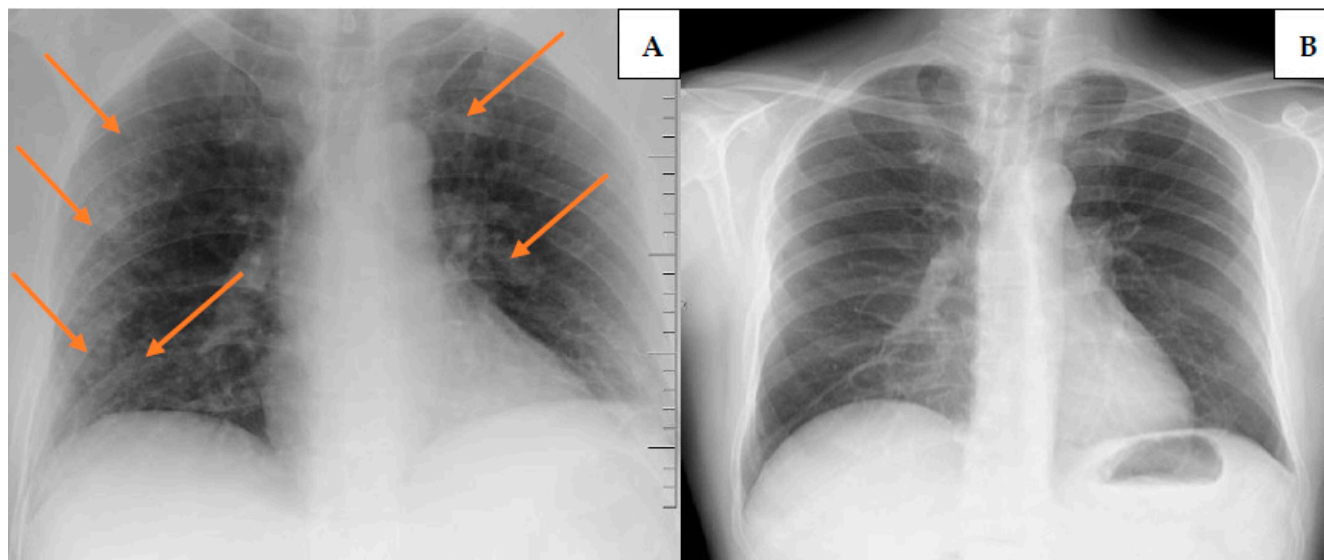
(A)—X-ray of the chest showing bilateral opacifications (arrow), (B)—Control X-ray of the chest (after 2 weeks)—regression of the finding.
